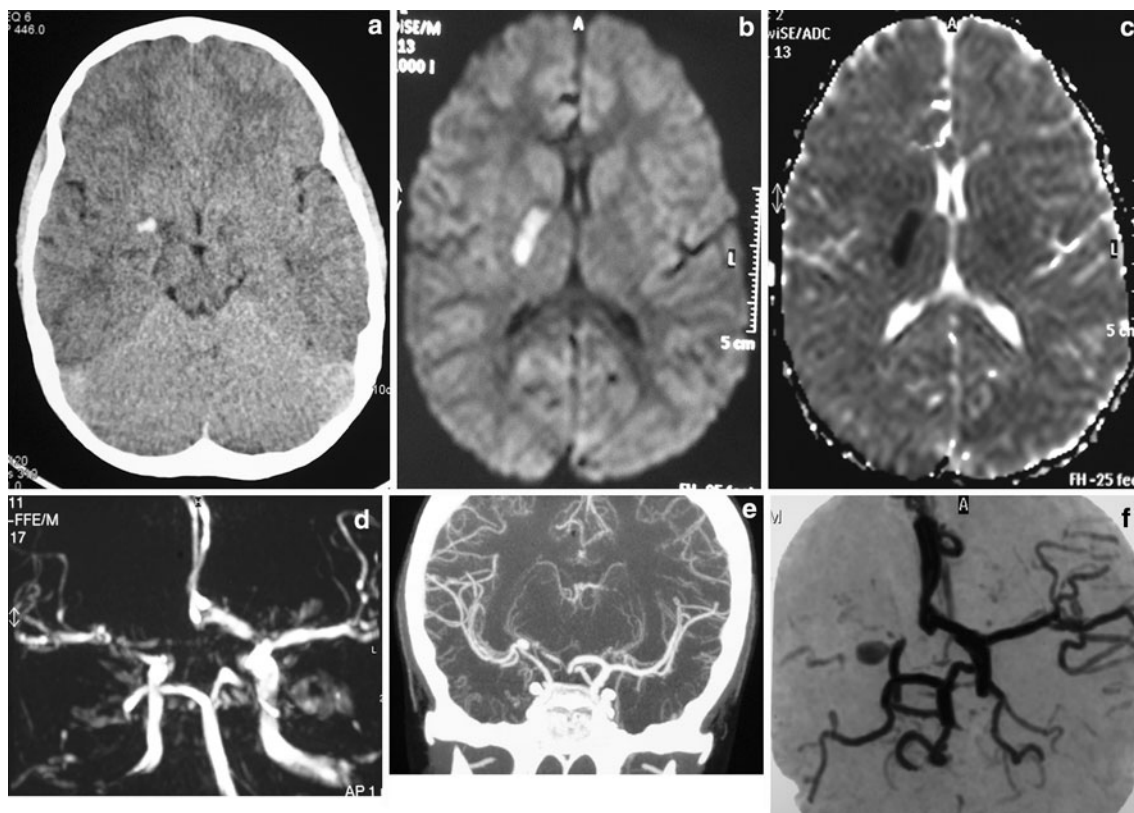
a CT scan performed in emergency room after 6 h from symptoms onset (right hemiparesis 2/5); hyperdense image on the right MCA; b brain MRI showing ischemic area, hyperintense on DWI sequences; c brain MRI—ADC sequences; d angio-MRI after the hospitalization showing aneurysm of the MCA with associated stenosis of the vessel; patient started LMWH infusion (right
